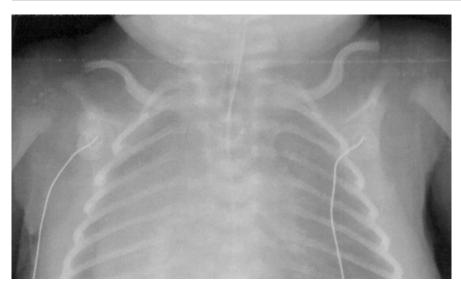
Radiographic features of rhizomelic chondrodysplasia punctata. A stippled ossification pattern is present in the proximal humeral epiphyses bilaterally.
